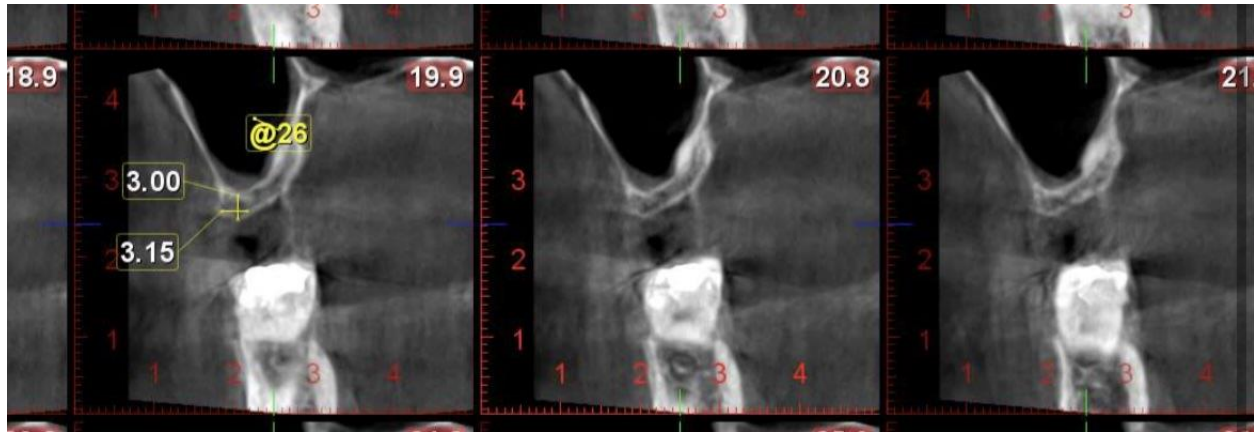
CBCT showing inadequate bone height and width
